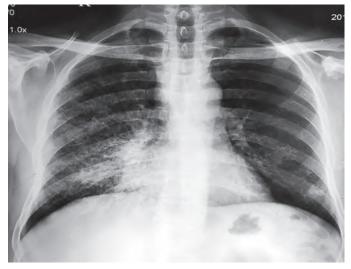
Chest radiograph: Bronchopneumonia
